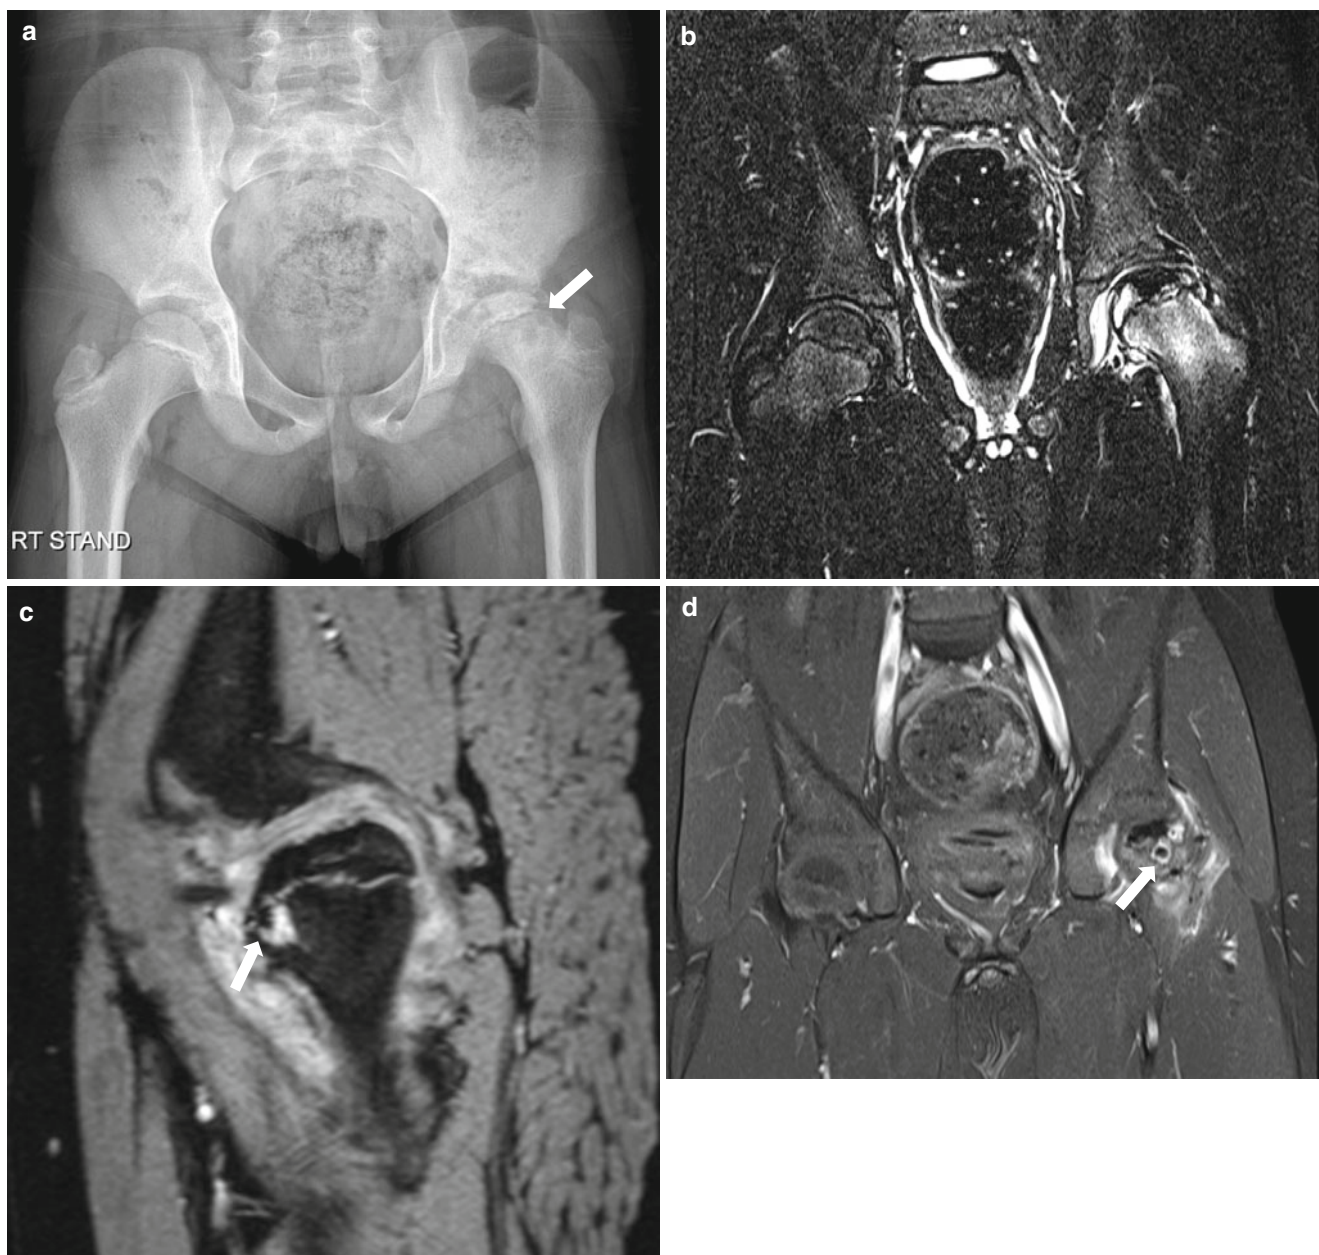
LCP disease with metaphyseal changes. (a) Anteroposterior radiograph of a 9-year-old boy shows irregular sclerotic and lytic lesion in the left femoral head and associated radiolucency in the left proximal femoral metaphysis (*arrow*). (b) Coronal T2-weighted MR image shows heterogeneous signal intensity of the left proximal femoral epiphysis with diffuse increased signal intensity in the left proximal
